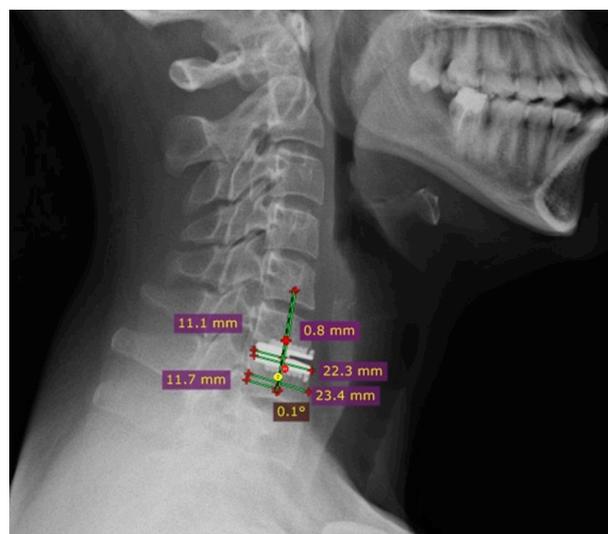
Postoperative plain radiograph at 6 weeks follow up. Lateral view and distance of center of disc from center of rotation.
